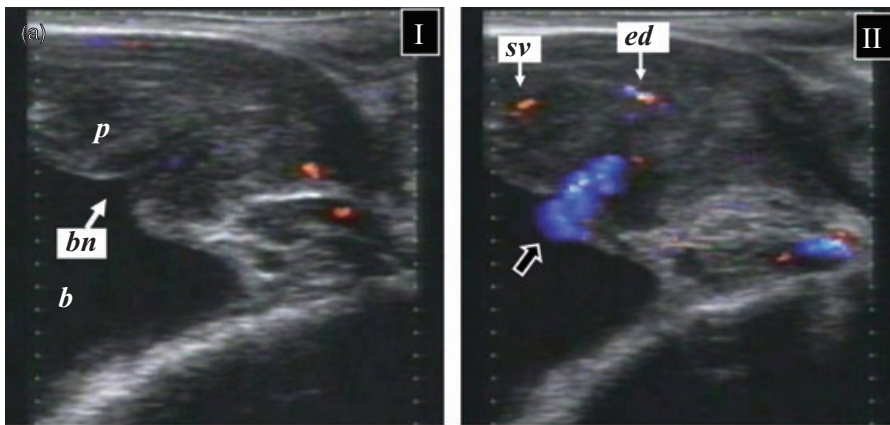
Color Doppler ultrasonographic images of ejaculation in case 1. (a) With oral silodosin. (I) Prostate (*p*), bladder (*b*), and opening of bladder neck (*bn*). (II) Seminal fluid stream (black arrow) flows slowly out of the seminal vesicle (*sv*) through the ejaculatory duct (*ed*) into the bladder. (b) Without oral silodosin. (I) Bladder neck (white arrow) does not open. (II) Ejaculatory stream (black arrow) from the seminal vesicles (*sv*) spurting towards the bulbous urethra (*bu*) through the ejaculatory duct (*ed*).
